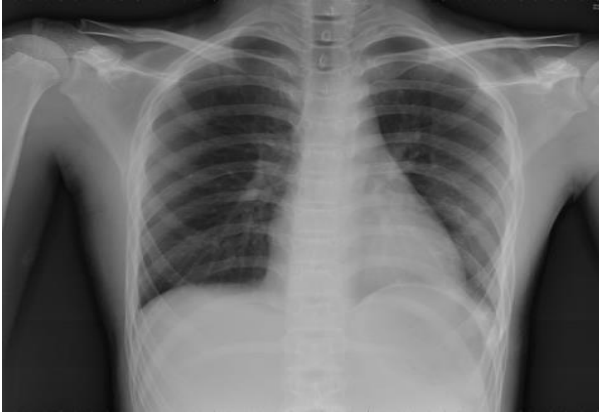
Chest radiograph of the patient after retrieval of the dislodged pectus bar.
